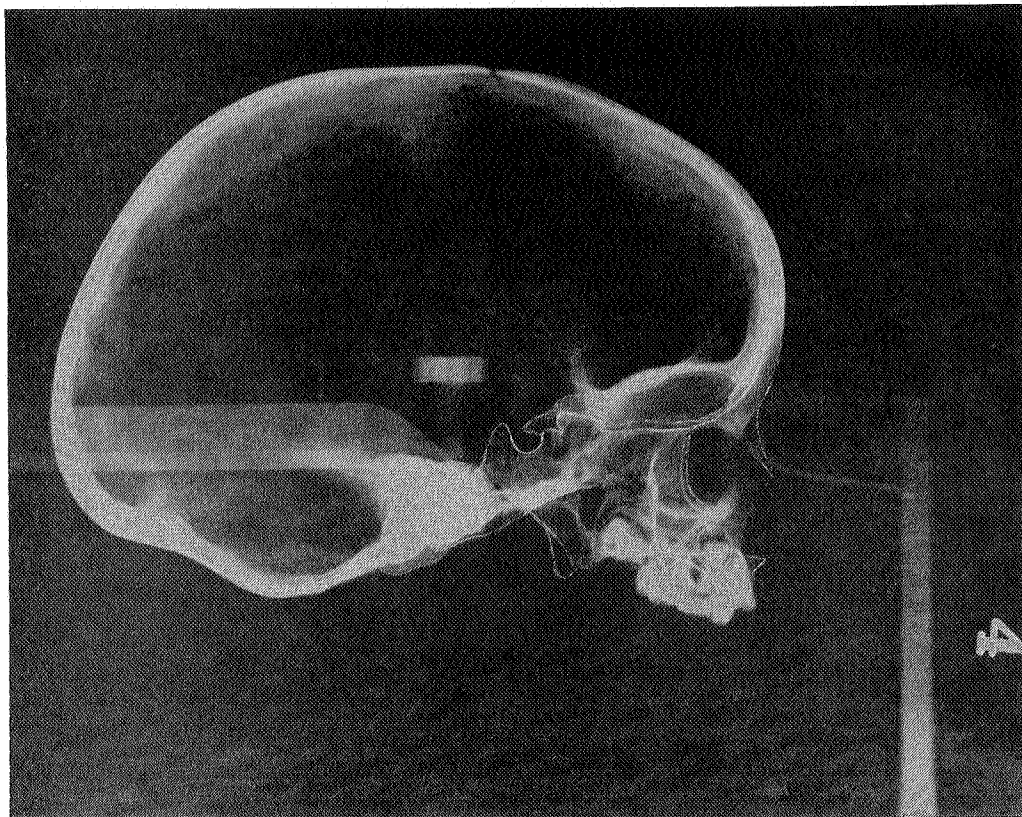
Lateral cephalometric radiograph of 4 year old skull (note irregular outline of tuberculum sellae area due to lack of complete fusion of pre and post sphenoid).
